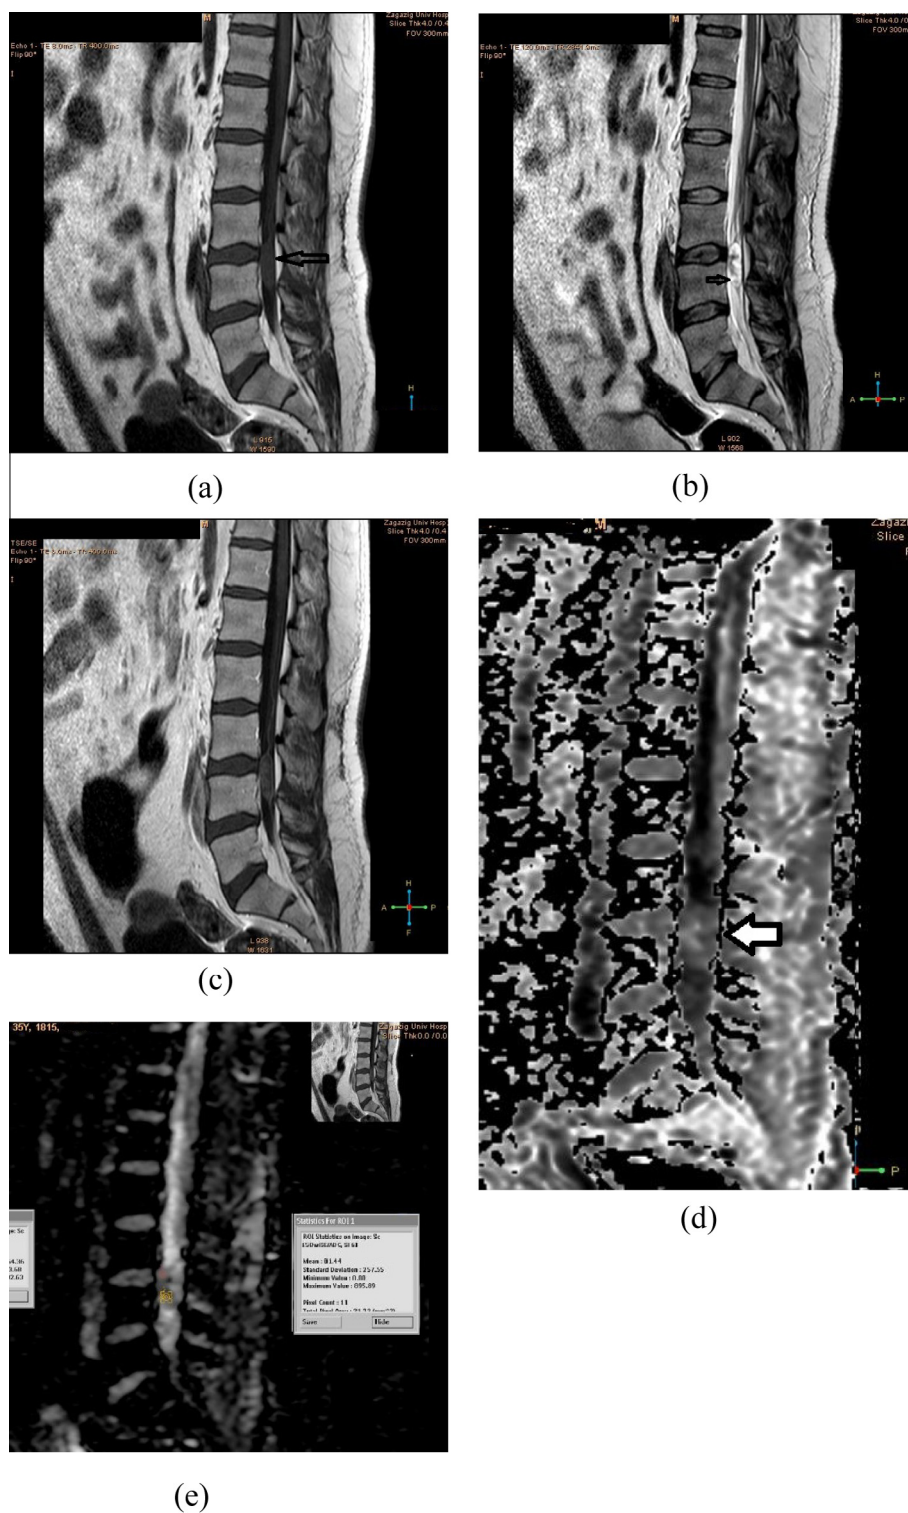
35-years-old male patient presented with low back pain since 4 months. (A) Sagittal T1WI shows heterogeneous isointense well defined oval shaped lesion (arrow) is seen at the distal part of the cord at the filum terminalis. (B) Sagittal T2WI shows heterogeneous hyper intensity of the lesion (arrow). (C) Sagittal post contrast image shows mild heterogeneous enhancement. (D) Sagittal DWI showed isointensity with central high signal area denoting restricted diffusion. (E) ADC map shows hyperintensity of the lesion denoting restricted diffusion. ADC value was $0.8 \times 10^{-3} \text{ mm}^2/\text{sec}$. The lesion has DWI readings suggestive of restricted diffusion. The findings of conventional MRI with DWI data, the case was diagnosed as myxopapillary ependymoma (low grade).
